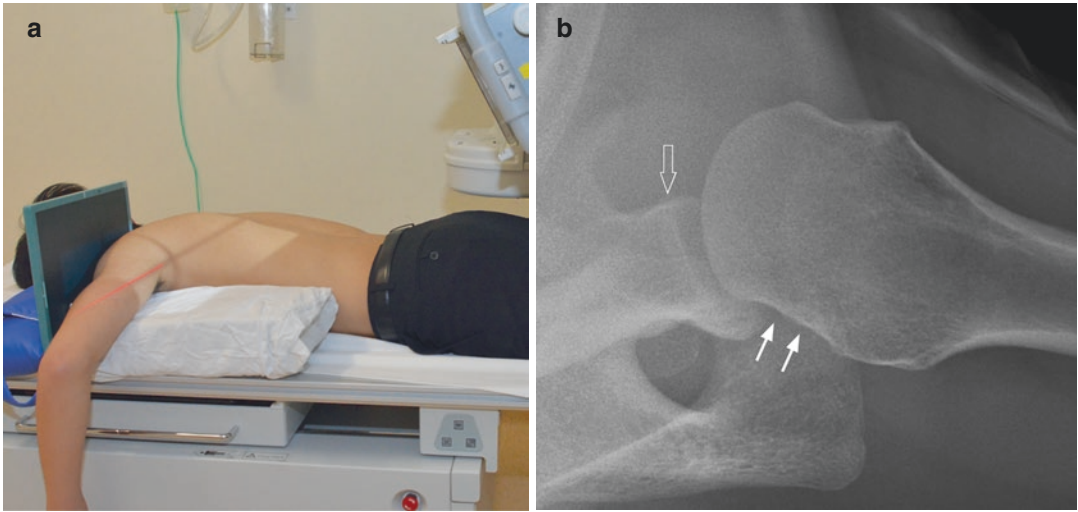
(a) Radiographic positioning for West Point view. (b) West Point view is used to evaluate the anterior glenoid rim for fracture and anterior glenoid bone loss
